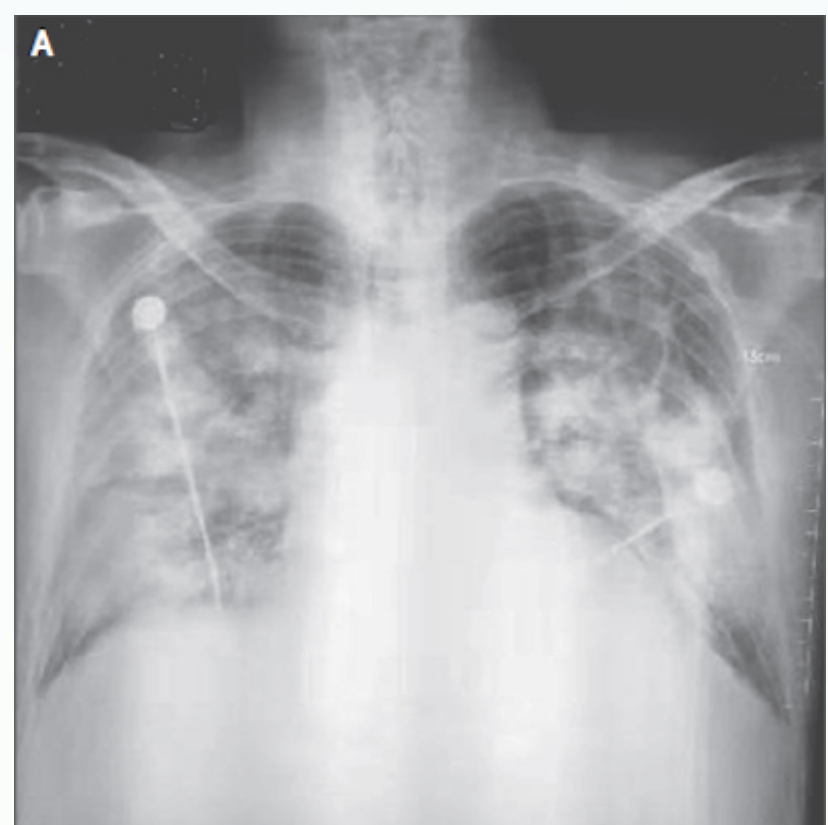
COVID-19 Lung X-Ray 3-5 Days after Respiratory Symptoms Begin
